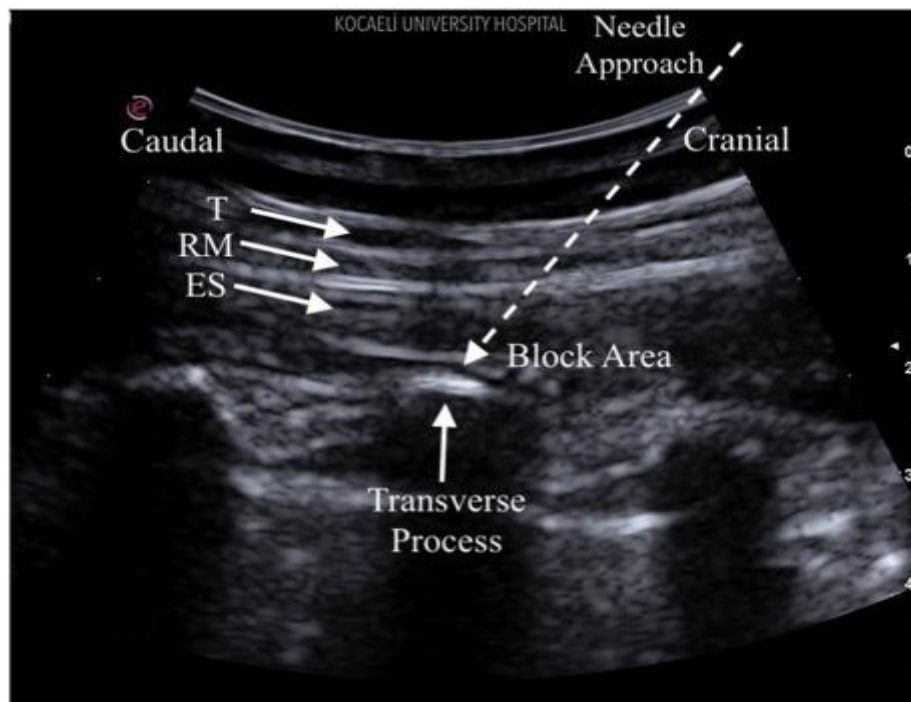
Ultrasound image of erector spinae block. T: Trapezius, RM: Rhomboid major, ES: erector spinae (23).
